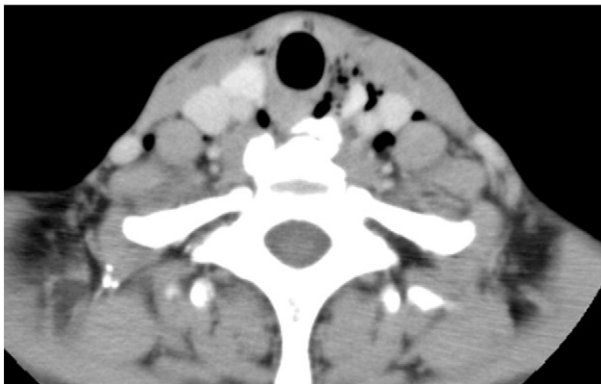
CT scan. Neck CT showed some air in the deep neck space.
